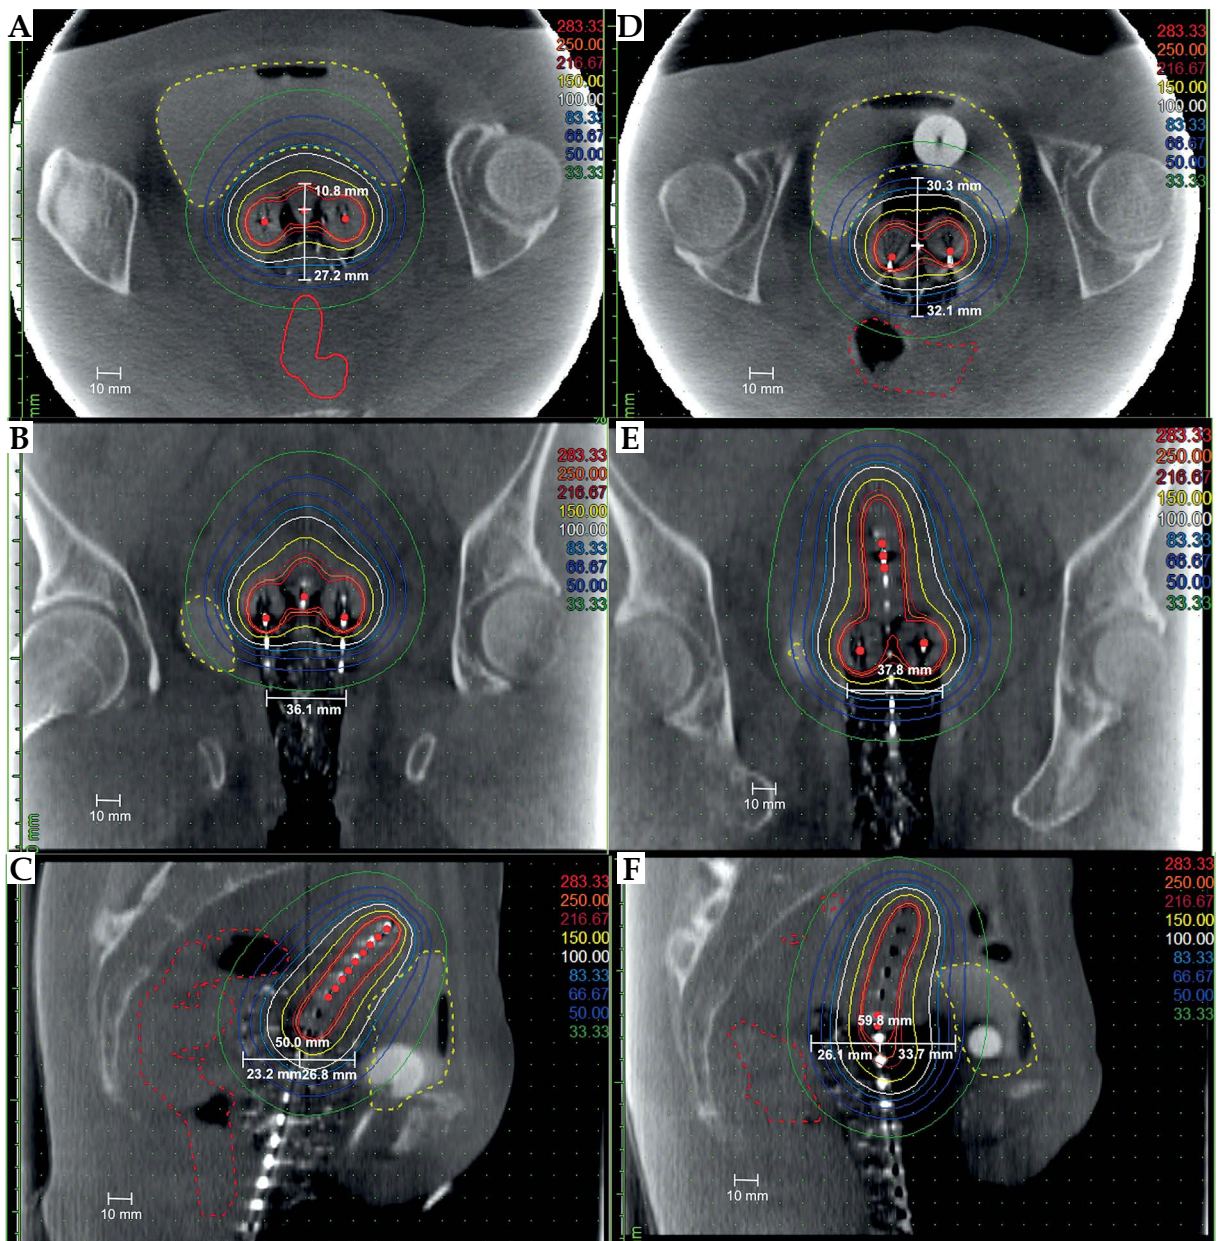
Representative computed tomography images and dosimetry planning intra-patient comparison of gauze packing and speculum-based vaginal packing (SBVP). Images correspond to case 1 dosimetry information in Table 3. Measurements indicate distance from the source to vaginal mucosa with the origin placed at posterior aspect of right ovoid. Isodose lines indicate the percentage of the prescribed dose. A) Gauze packing axial. B) Gauze packing coronal. C) Gauze packing sagittal. D) SBVP axial. E) SBVP coronal. F) SBVP sagittal
